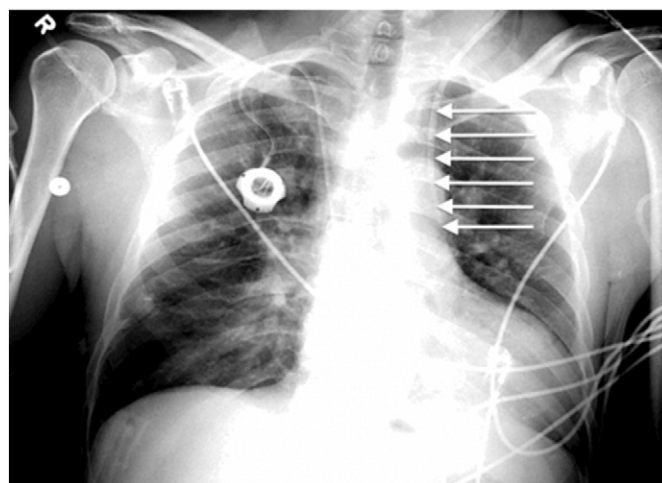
Routine chest radiograph showing a left-sided central venous catheter (arrows) that is not crossing the midline. A right subclavian Mediport (Bard Access Systems, Inc., Salt Lake City, UT, USA) is also seen.
